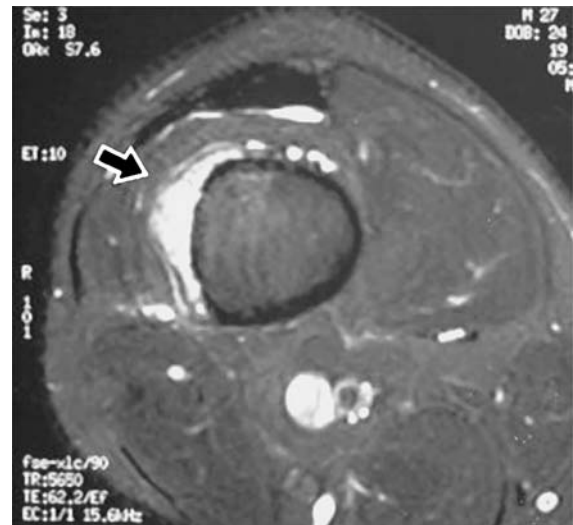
An axial FSE fat-suppressed T2-weighted image reveals a sharply defined crescent-like periosteal soft-tissue mass abutting the cortical excavation. The mass has a homogeneous high signal intensity (arrow). The medulla has normal signal intensity
